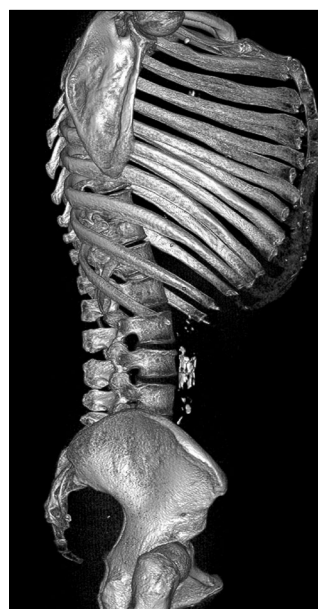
Computed tomography reconstruction of the rib cage showing that the sternum has a normal length and is not depressed in the lower third.
